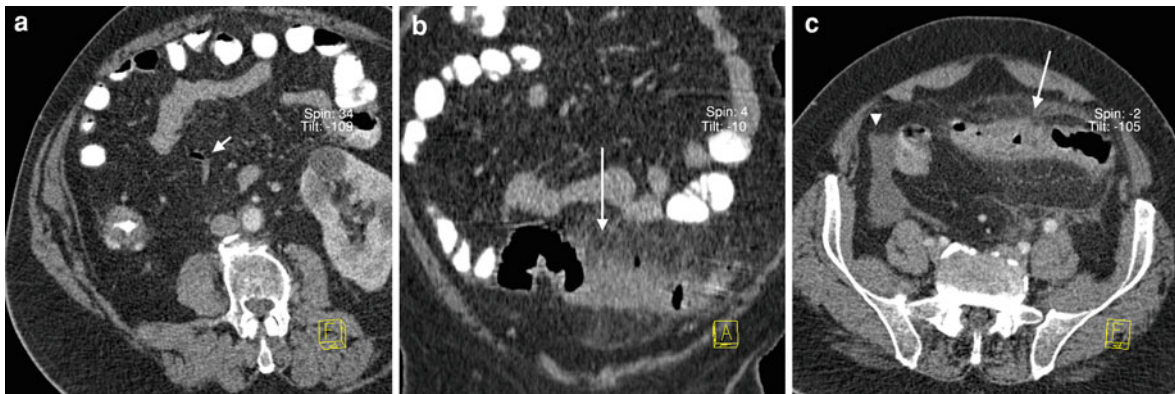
CT images obtained with oral and IV contrast in a patient suspected of acute appendicitis with a definite diagnosis of acute sigmoid diverticulitis. a 3 mm oblique reformation image. The normal appendix is filled with air (*short arrow*) but not by oral contrast administered one and half hour before.
